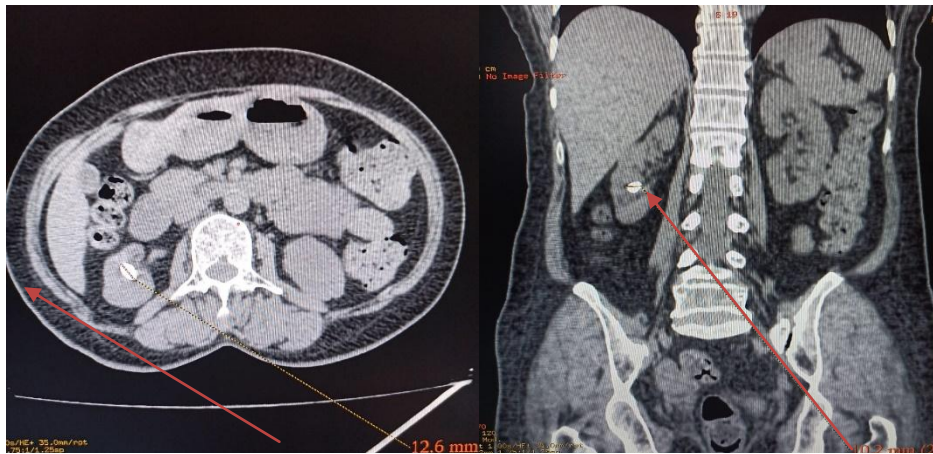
a: CT KUB axial view and b: CT KUB coronal view showing calculus in lower pole of right kidney
